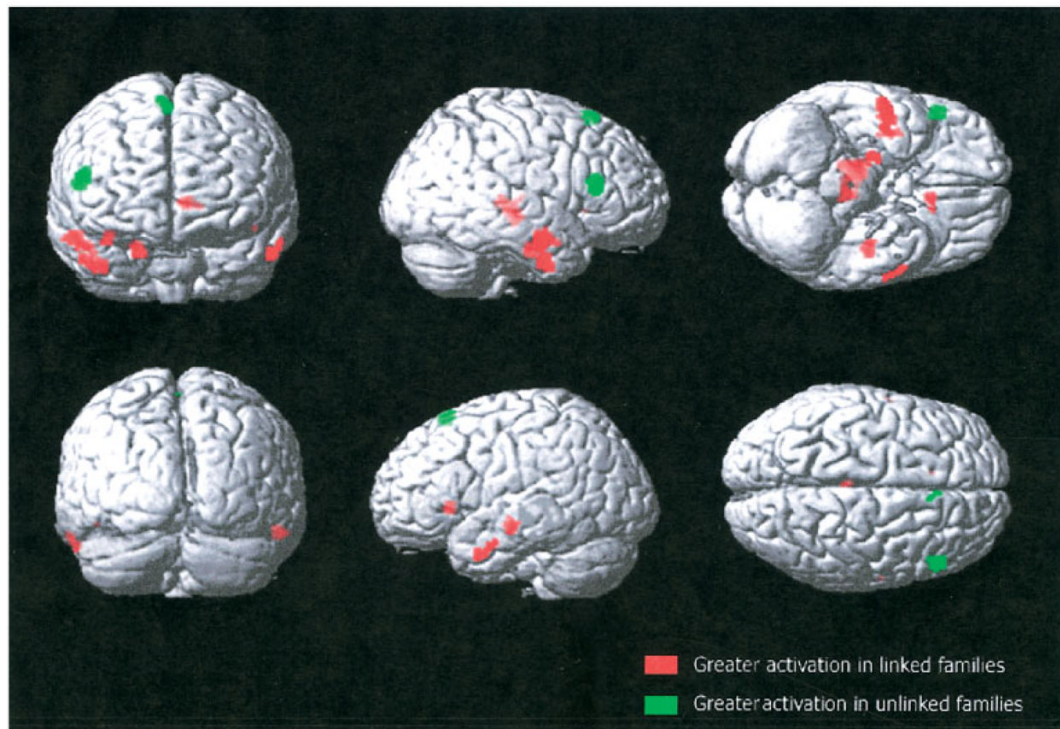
This is a representation of two contrasts of the functional magnetic resonance imaging activation during verbal encoding. There is increased activation in linked families in temporal areas (shown in red), whereas unlinked families show a very different pattern of activation, mainly localized in the frontal lobes (shown in green).
